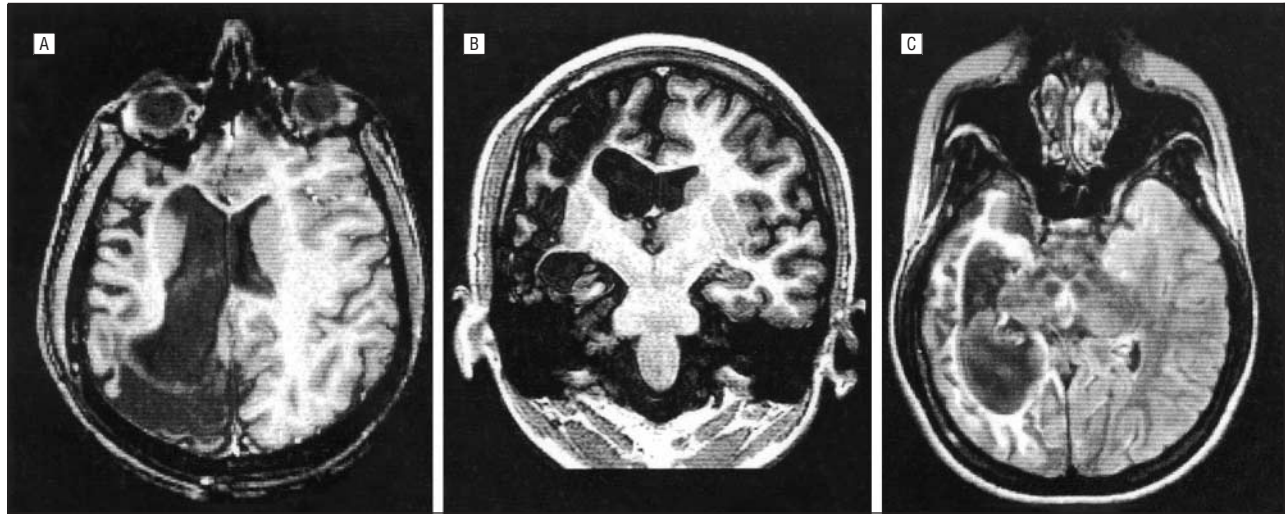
A, T1-weighted magnetic resonance imaging of the axial plane showing diffuse right cortical and subcortical destruction. B, T1-weighted magnetic resonance imaging of the coronal plane showing a cortical and subcortical atrophy of the right frontal and temporal lobes. C, Fluid-attenuated inversion recovery sequence magnetic resonance imaging of the axial plane showing *ex vacuo* lateral ventricle enlargement and widespread increased signal intensity in the subcortical portion of the right hemisphere, indicating gliosis.
